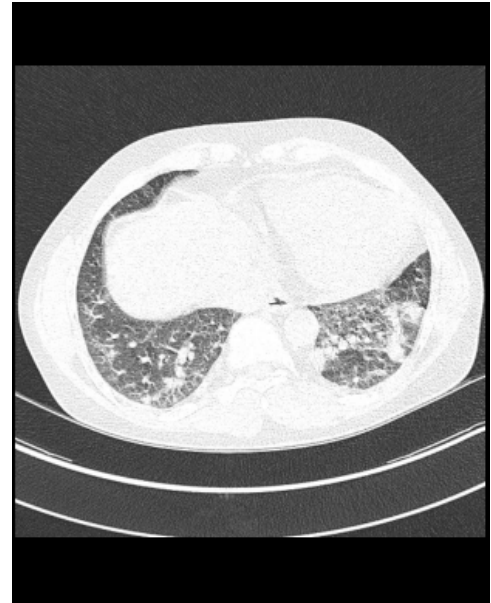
Initial CT scan The CT scan reveals a patchy consolidative pattern, ground glass appearance as well as thickened interstitial septa, nodular components and peribronchial cuffing. This indicates acute interstitial inflammatory component and air spaces filled with liquid.
